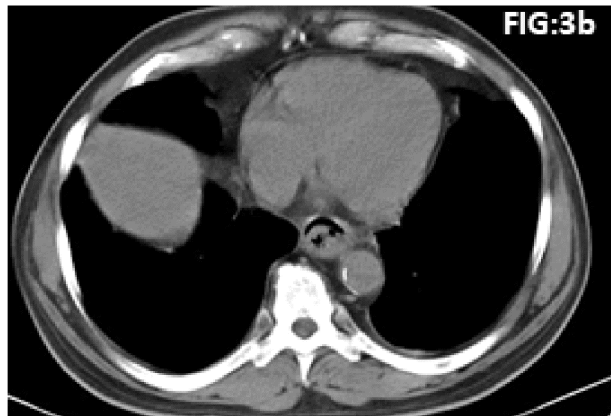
follow up CT Follow up CT performed a week later showing partial resolution of the hematoma
